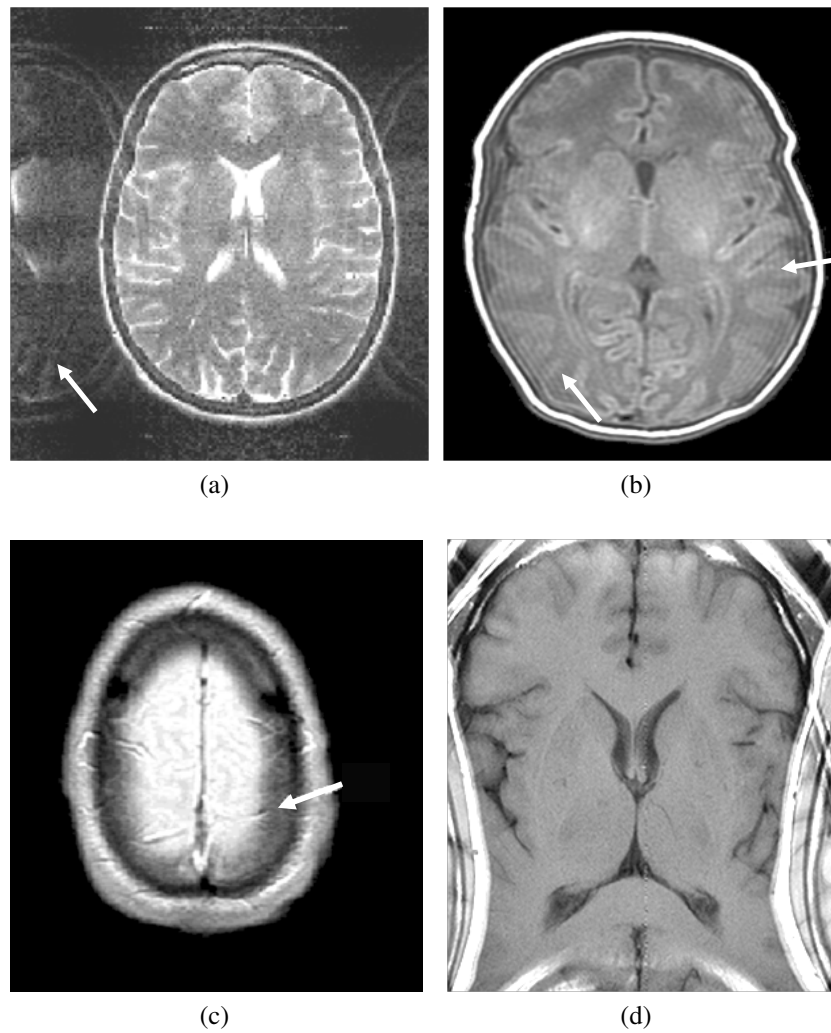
MR imaging artifacts: (a) the ghosting effect (caused by the movement of the patient in the scanner), (b) the Gibbs phenomenon (ringing), (c) the partial volume effect (PVE) and (d) the aliasing (wrap-around).
